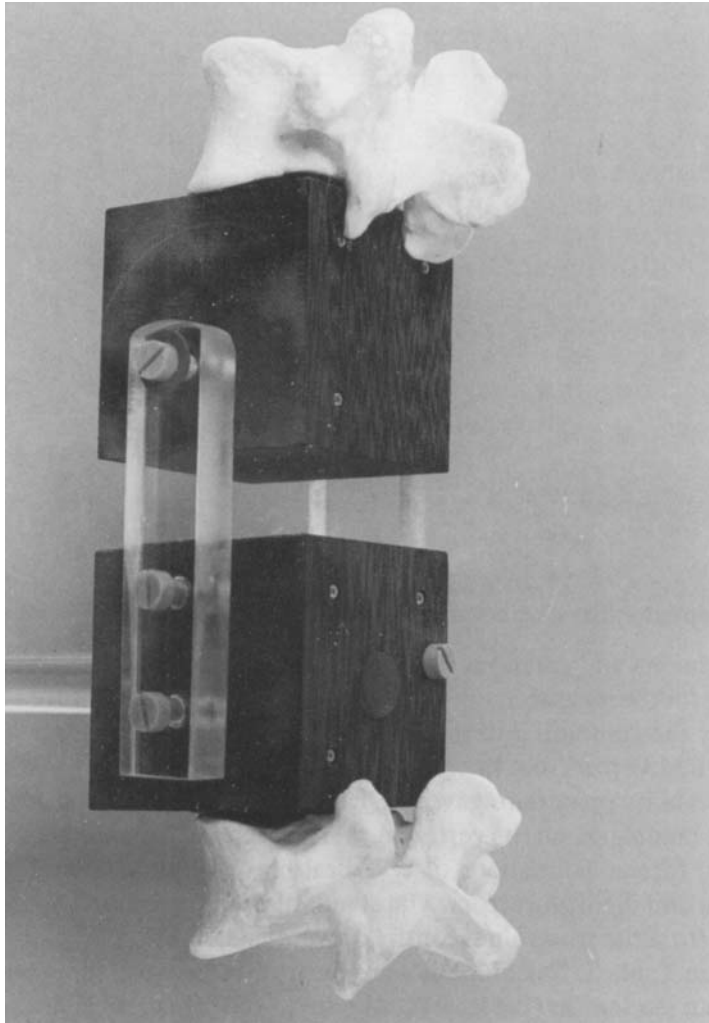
The model used to assess the accuracy of the biplanar radiographic measurements.
